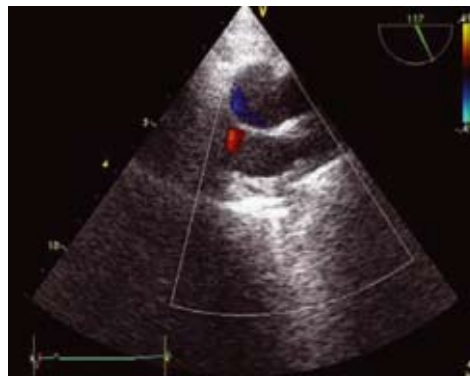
A-Large clot in high transesophageal long axis view of SVC
